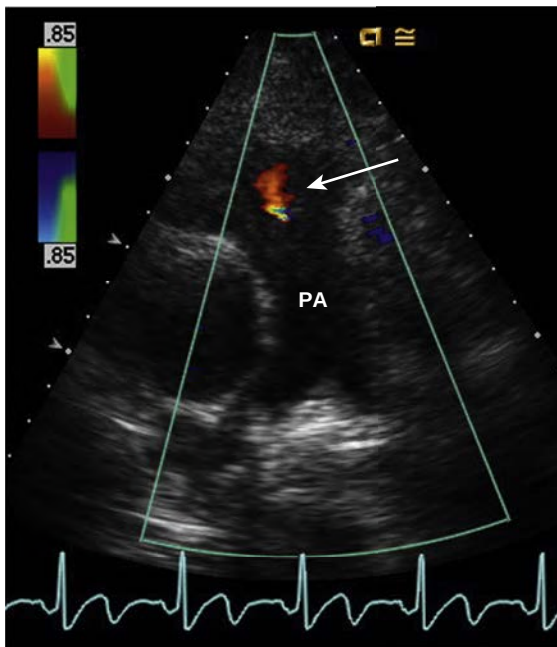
Color Doppler of pulmonic valve regurgitation. Color Doppler in a RV outflow view showing a narrow jet of pulmonic regurgitation (arrow) in diastole. Mild pulmonic regurgitation is seen in about 80% of normal adults. PA, Pulmonary artery.
